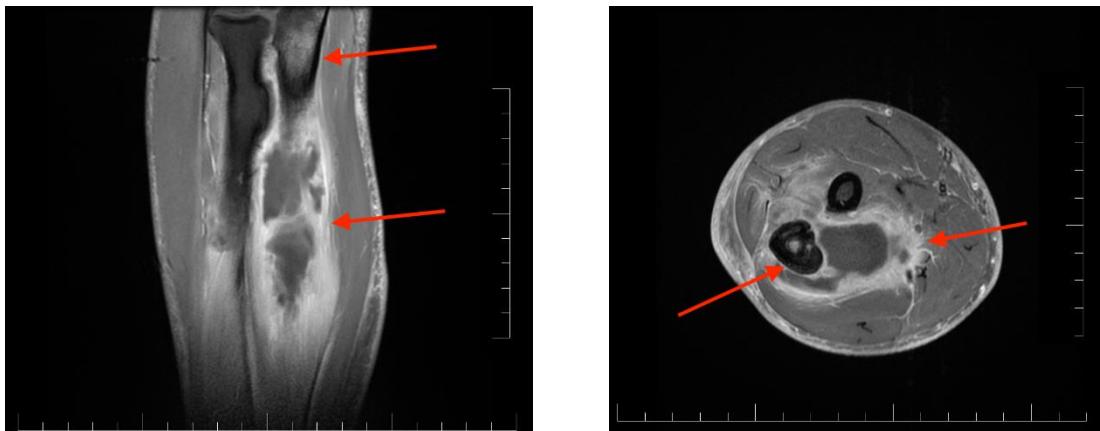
MRI of the forearm with contrast agent, extensive abscess and pathology in the proximal part of the ulna (sagittal and coronary section).
